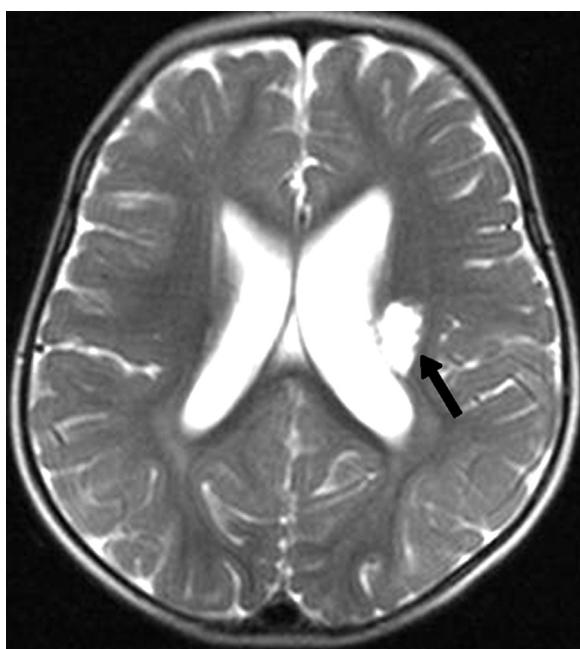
Late subacute-chronic infarction (black arrow) on axial T2-weighted magnetic resonance imaging after 3 wk.
